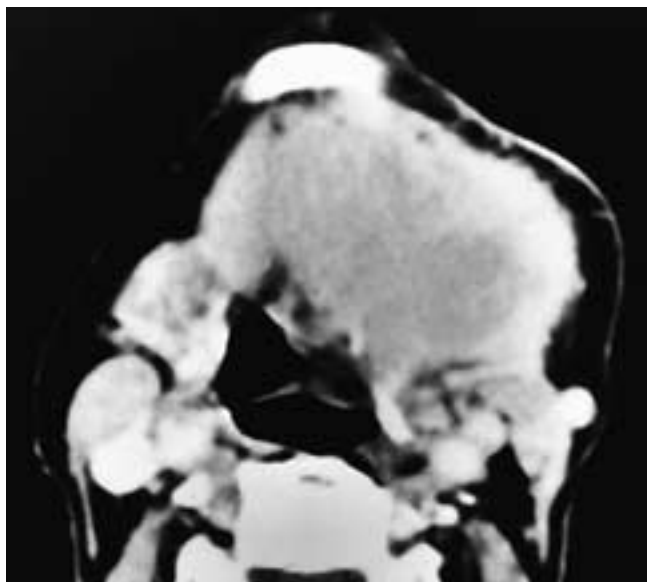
Axial contrast-enhanced CT scan shows a large, infiltrating mass of the left submandibular gland. The tumor has invaded the floor of the mouth. This patient had an AdCC.
